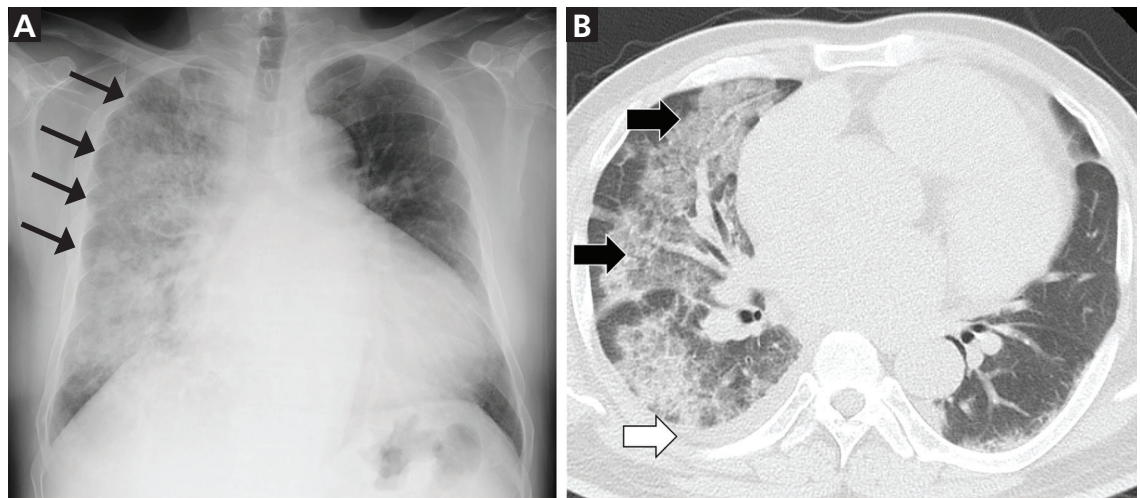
(Left) Chest radiography showed a right unilateral consolidation (arrows) and enlarged cardiac silhouette. (Right) Chest computed tomography revealed diffuse ground-glass opacities and consolidation (black arrows) together with a small amount of pleural effusion in the right lung (white arrow).
